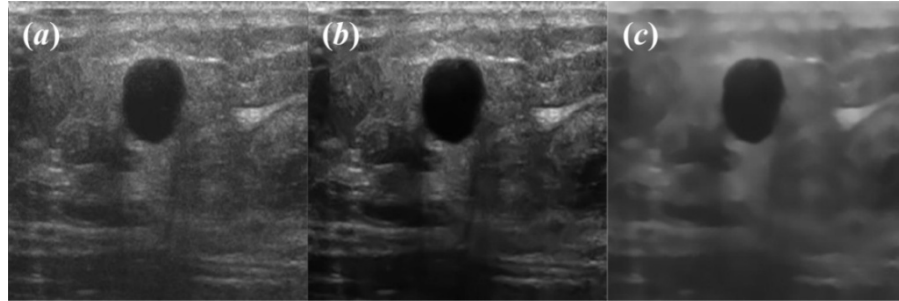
(a) Sample original ultrasound image of benign tumor and (b), (c) corresponding images despeckled by (b) OBNLM filter and (c) PPB filter.
